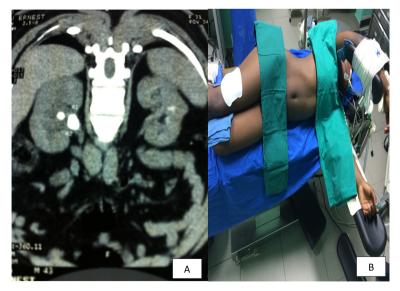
CT scan showing obstructive right renal pelvis stone (A) and patient placed in the left lateral position prior to surgical intervention (B).
